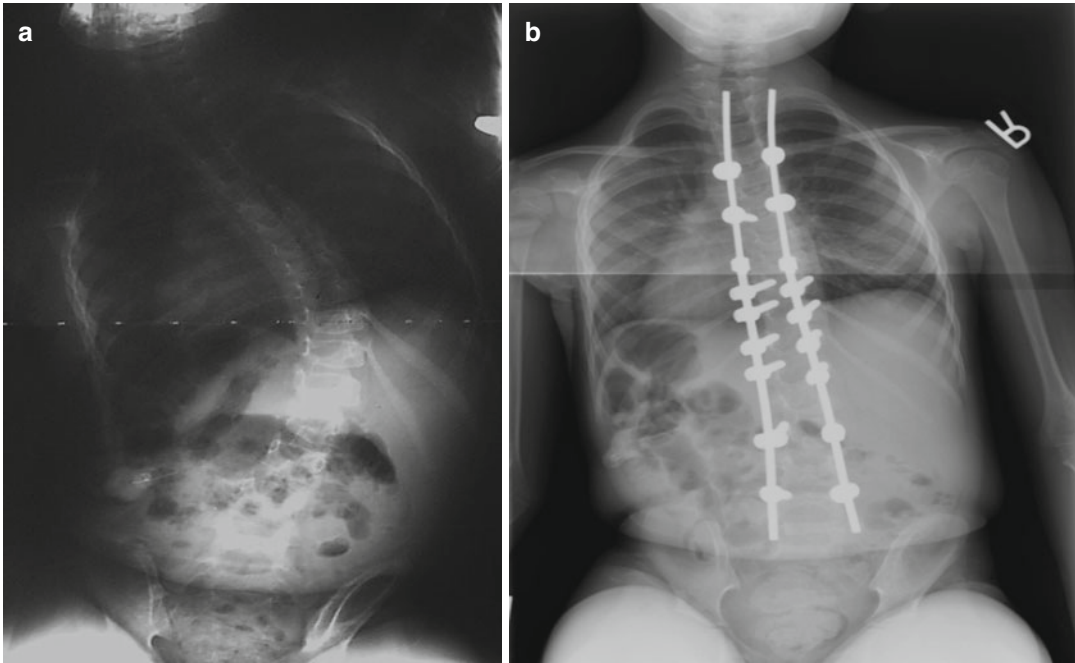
(a, b) (a) Sitting preoperative AP spine radiograph of a 4-year-old with Dandy–Walker syndrome and spastic neuromuscular scoliosis with mild–moderate
